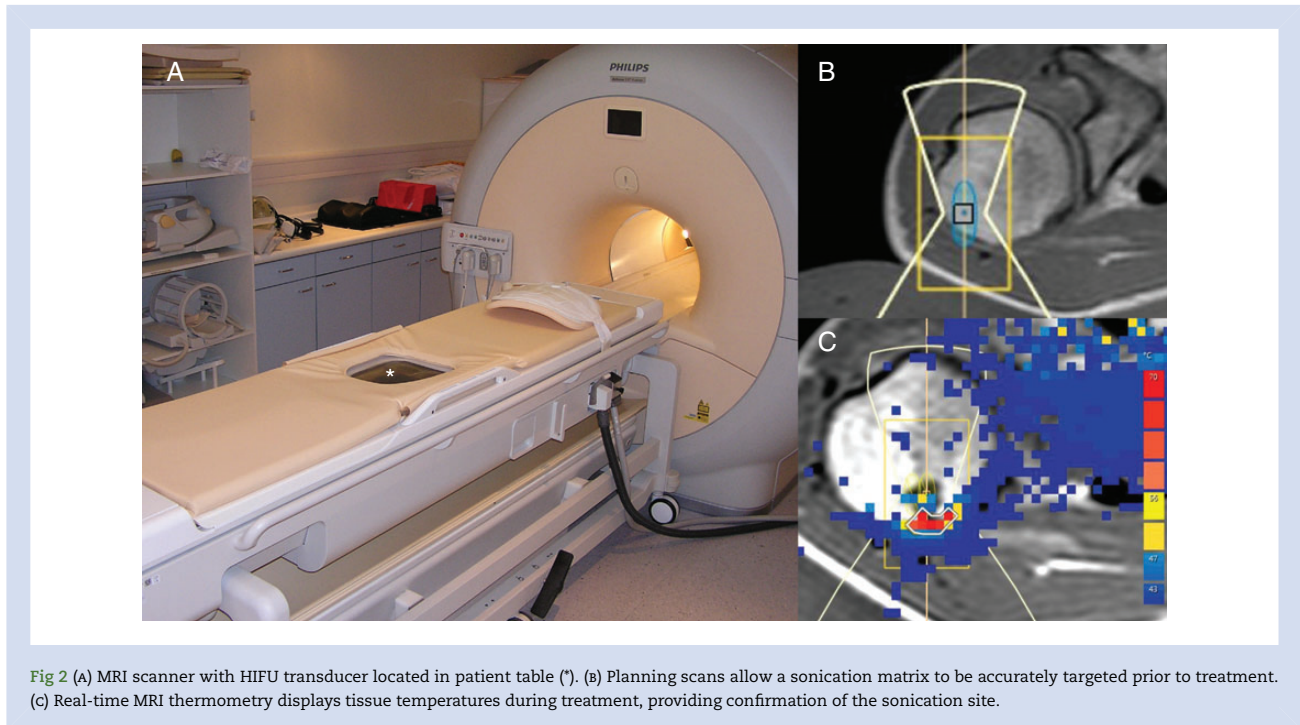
(A) MRI scanner with HIFU transducer located in patient table (*). (B) Planning scans allow a sonication matrix to be accurately targeted prior to treatment. (C) Real-time MRI thermometry displays tissue temperatures during treatment, providing confirmation of the sonication site.
